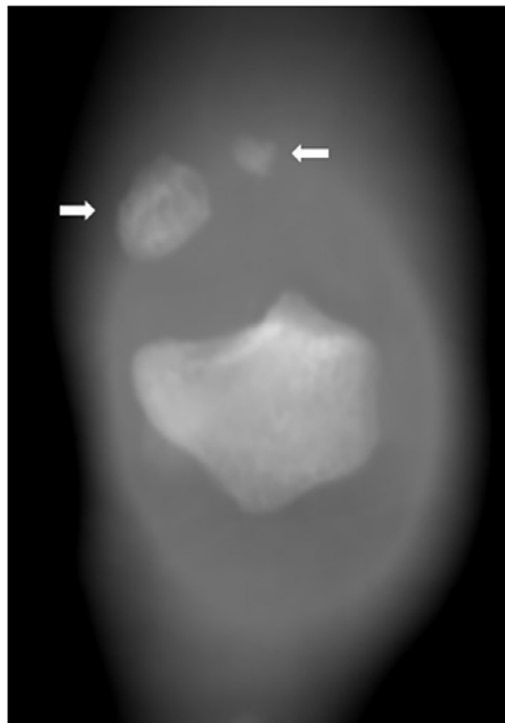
Coronal maximum intensity projection CT image demonstrates a superolateral defect within the patella with two well-corticated fragments (arrowheads) which are displaced superiorly due to avulsion/separation.
